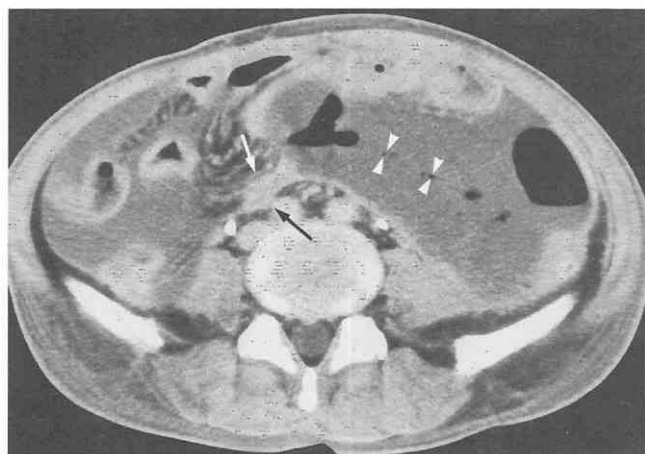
Strangulated small-bowel obstruction due to adhesions. CT scan shows a serrated beak (arrows) in the bowel loop at the site of obstruction. The bowel wall (arrowheads) in the strangulated segment has lost its definition. A large amount of ascites is present. (From Ha HK: CT in the early detection of strangulation in intestinal obstruction. *Semin Ultrasound CT MRI* 16:141-150, 1995.)
